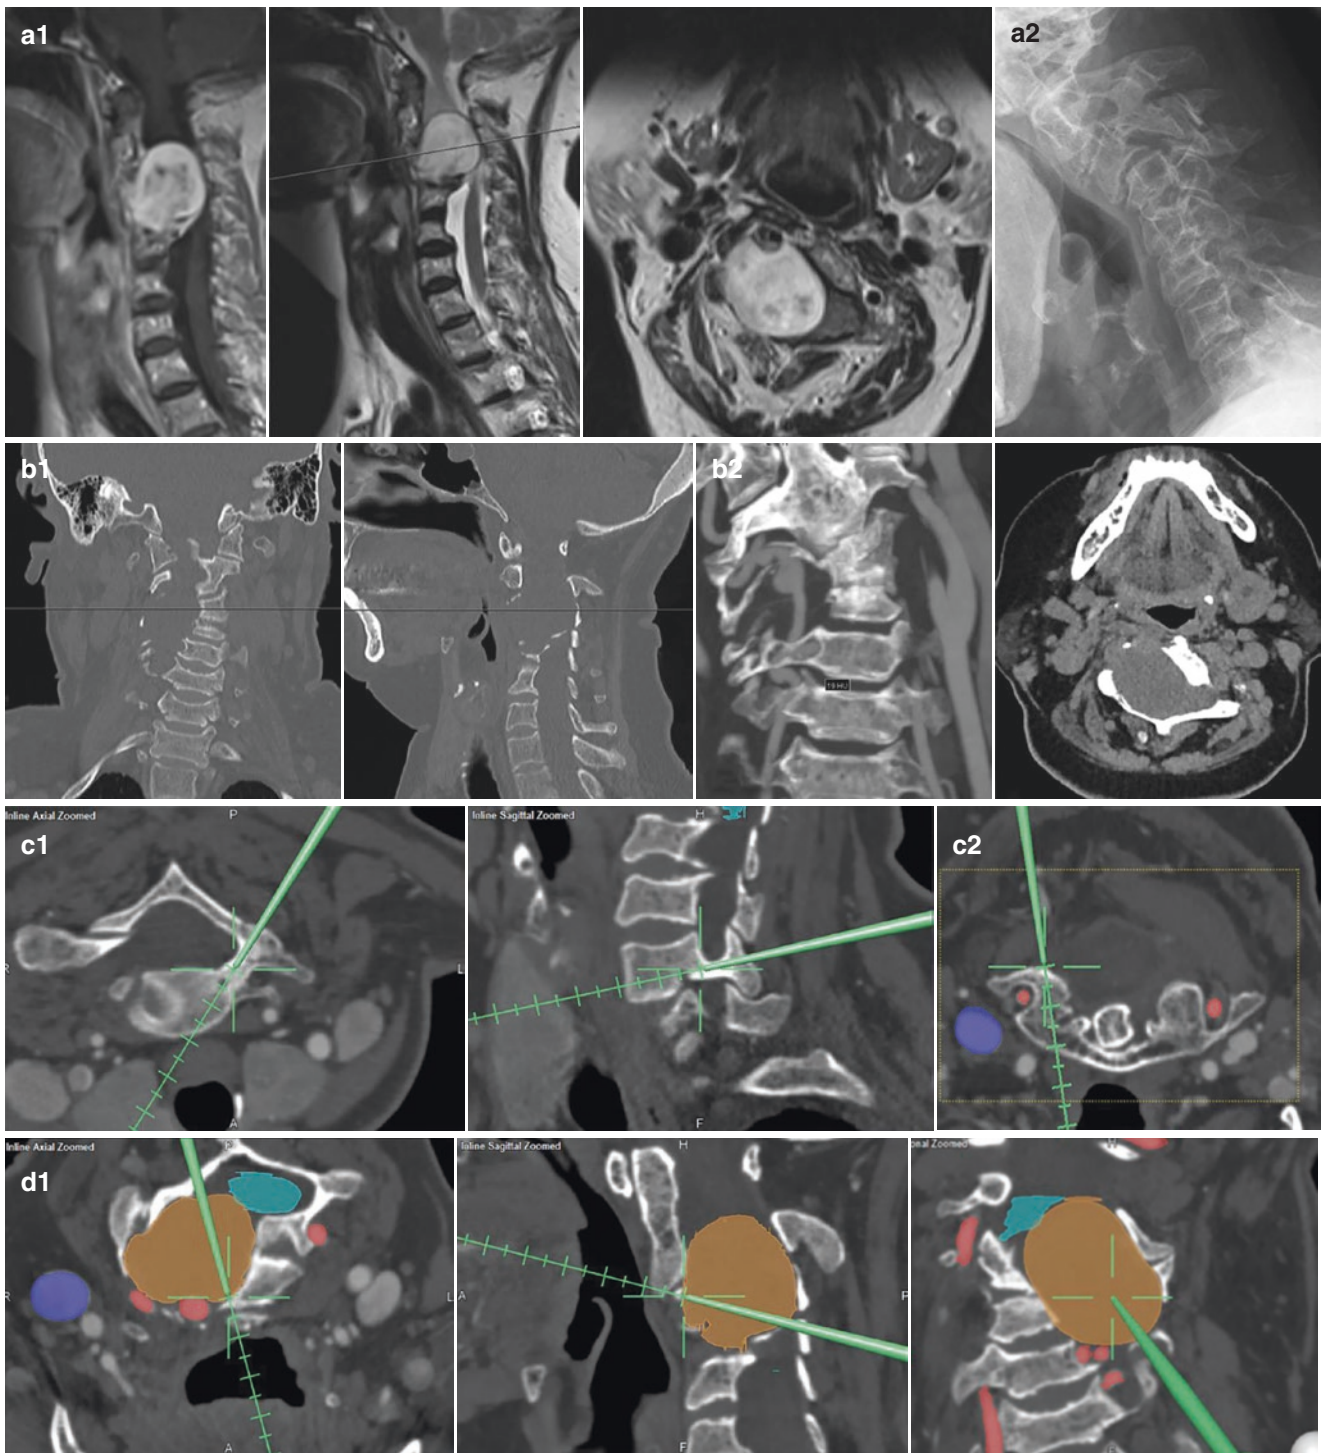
(a1) MRI T1 with contrast and T2. Large C3–C6 dumbbell nerve sheath tumour encasing vertebral artery. (a2) X-ray cervical spine—inversion of normal lordosis. Anterolisthesis of C3 on C4 vertebra. (b1) CT cervical spine and (b2) angio CT demonstrating scalloping of the vertebrae, abnormal looping vertebral artery with aneurysm. (c1) Postoperative MRI shows spinal cord decompression. (c2) Accurate placement of the screws
